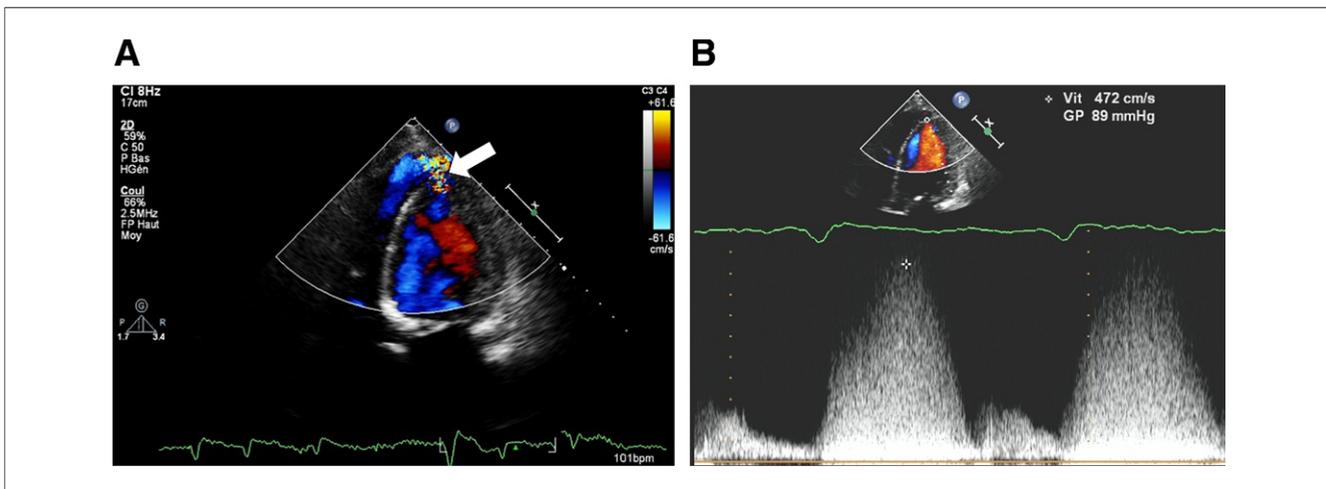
Color-Doppler Imaging of the Left-to-Right Flow
